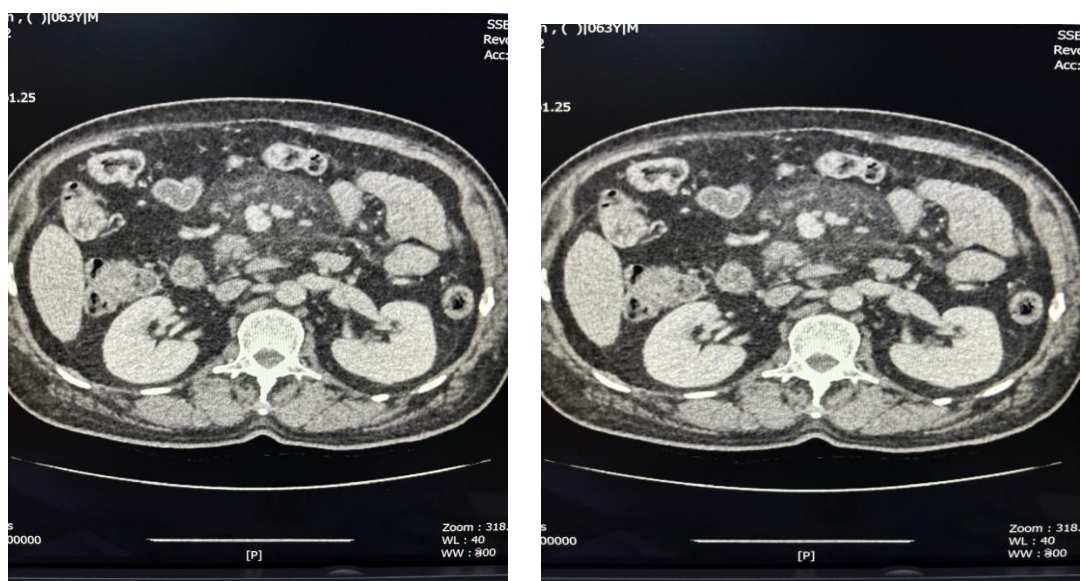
Figure C - Axial CT scan
